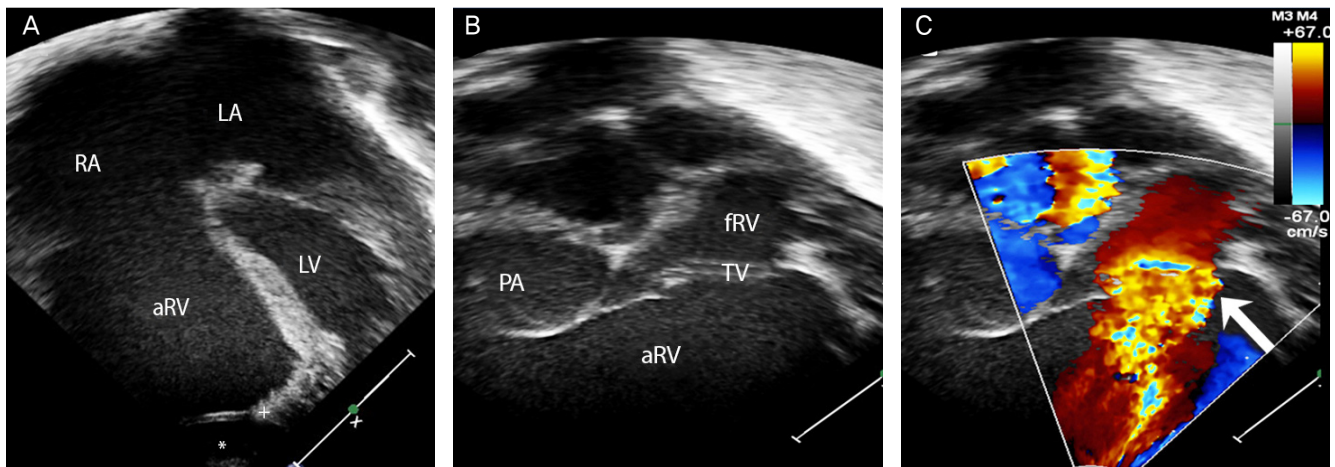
Postnatal echocardiogram showing an almost completely atrialized right ventricle (aRV) with only a small outlet portion operating as a functional RV (*) and a severe downward displacement of the tricuspid valve leaflet insertion site (+) (A). Right ventricular outlet view also showing a very small functional RV (B), and severe tricuspid regurgitation on color Doppler (arrow) (C). RA, right atrium; LA, left atrium; LV, left ventricle; aRV, atrialized right ventricle; PA, pulmonary artery; fRV, functional right ventricle; TV, tricuspid valve.
